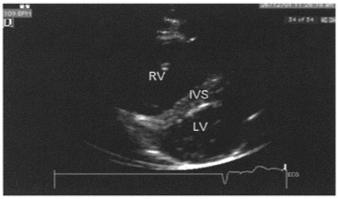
(A) Apical four-chamber view. Enlarged right ventricle (RV) dominating left ventricle (LV). At real-time scanning, hypokinesis of middle segment of RV free wall was present with preserved contractility of its apical segment (McConnell's sign; see text). RA: right atrium; LA: left atrium. (B) Flattened intraventricular septum (IVS) bulging into left ventricle present in short-axis parasternal view.
